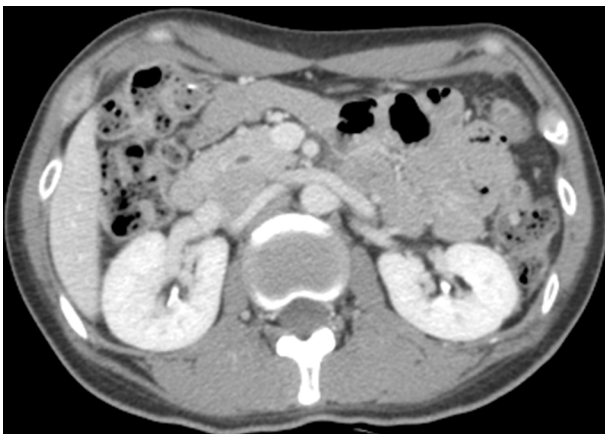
Axial CT image indicated no tumor recurrence in the left perirenal space, after 6 months of the operation.
